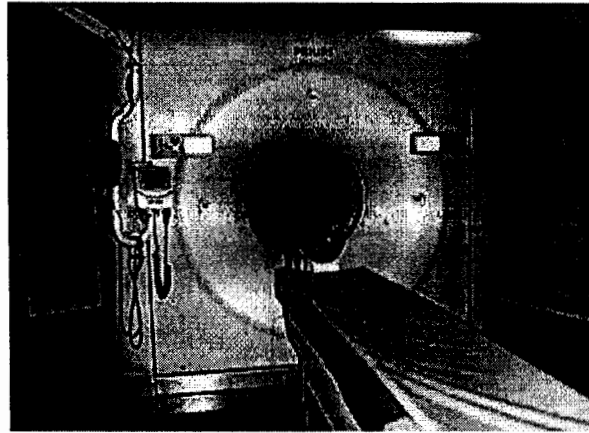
A Multislice CT Scanner [11]
